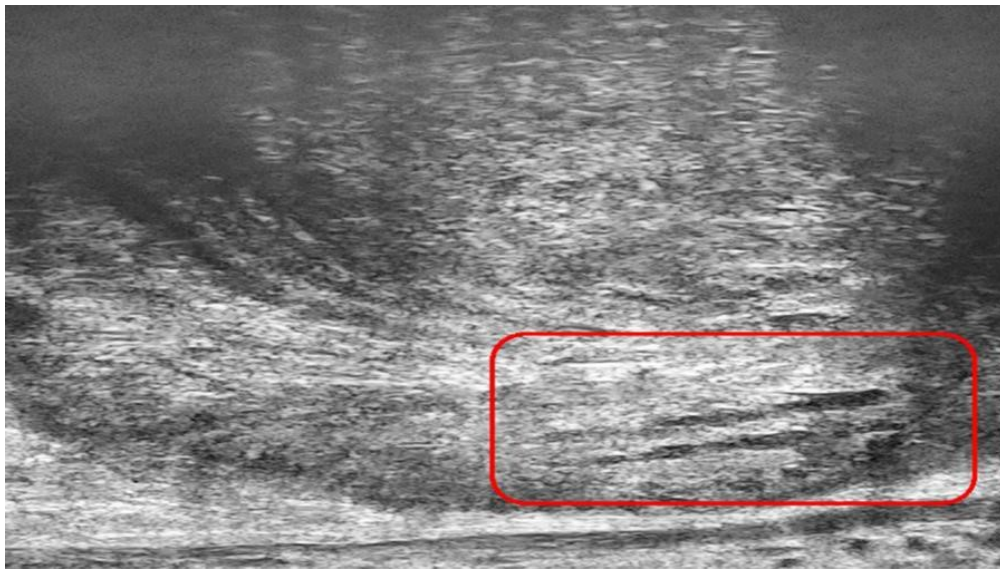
Micro-ultrasound: tracks of preceding biopsy of the prostate (two years prior)
